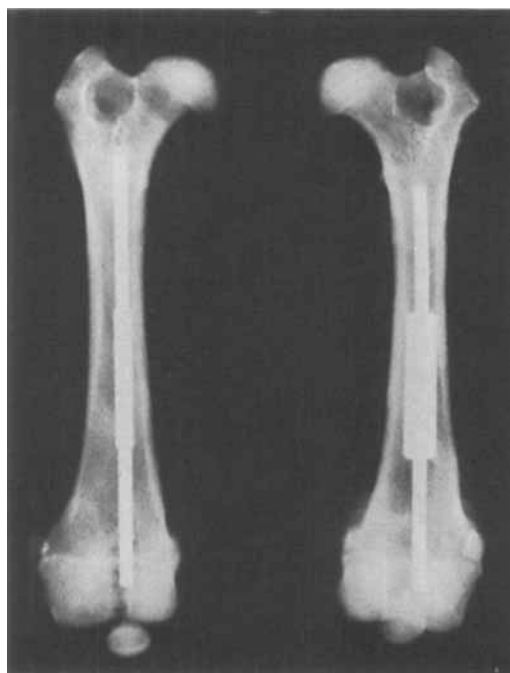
Post-mortem X-ray (16 weeks) showing the position of the implants within the femurs.
